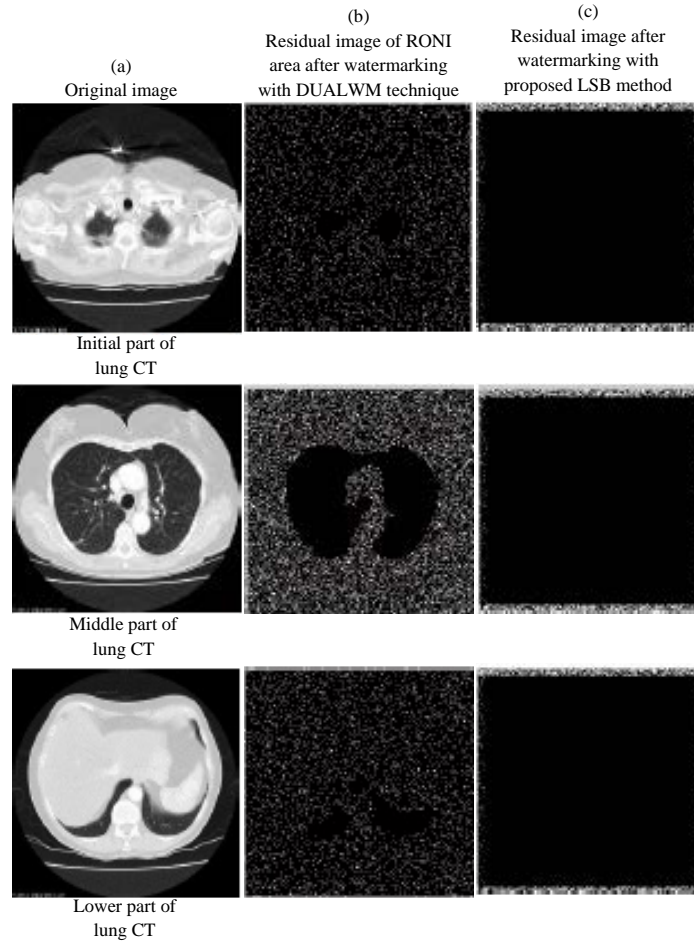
(a-c): (a) Original CT scan image, (b) Difference of original RONI and watermarked RONI when DUALWM technique was applied and (c) Difference of original border and watermarked border when proposed LSB method was applied
